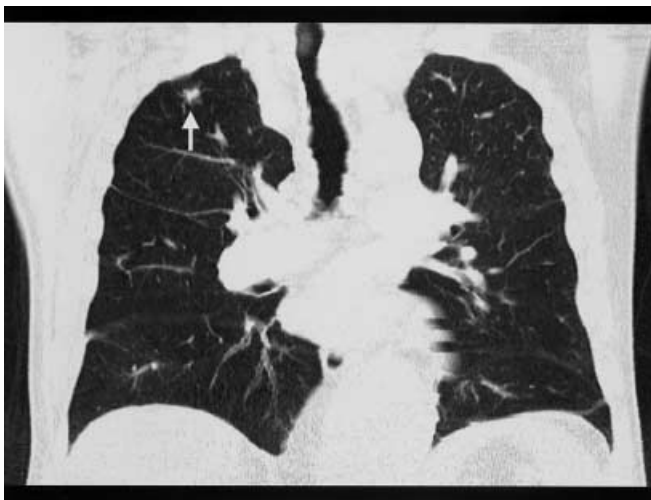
Incidentally found T1 peripheral adenocarcinoma (*arrow*) in the right upper lobe of a patient with central PE. Volume-rendered display of a contrast-enhanced high-resolution multislice CT pulmonary angiogram. Direct visualization of emboli and of relevant alternative or additional disease is the key advantage of CT over competing modalities for the diagnosis of PE
